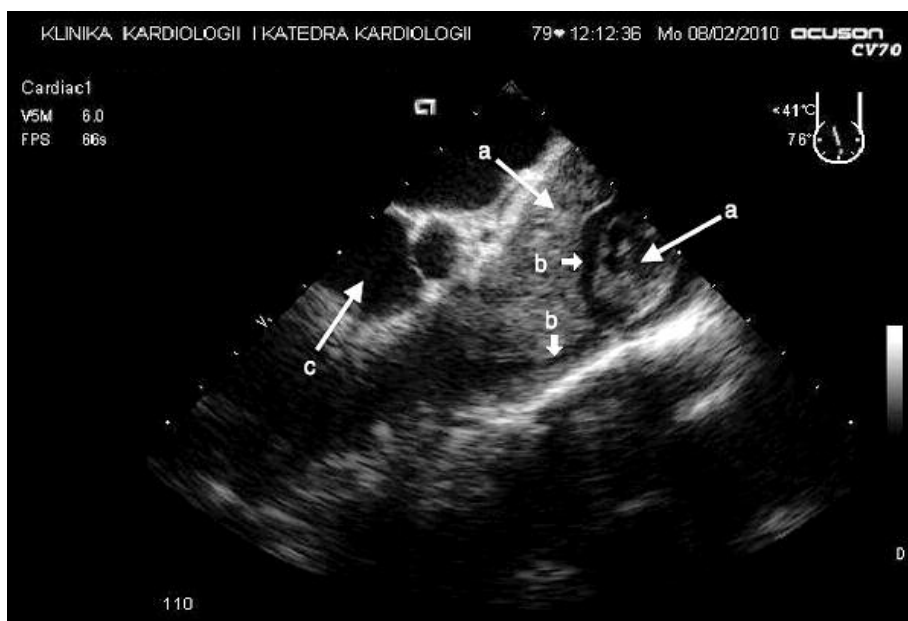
Echocardiogram: (a) tumor – intimal sarcoma in the enlarged pulmonary trunk, (b) residual canal via tumor mass which supplies blood flow to the pulmonary arteries (c) aortic valve
